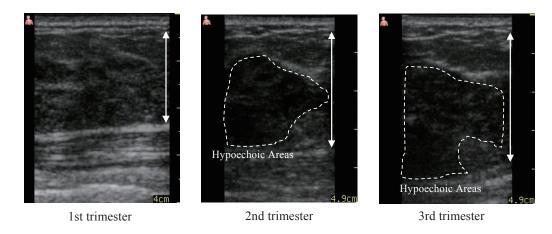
Pocket ultrasound images of the subject 7 (30s, multipara) who was easy to observe the change in image finding that the mammary gland becomes hypoechoic
